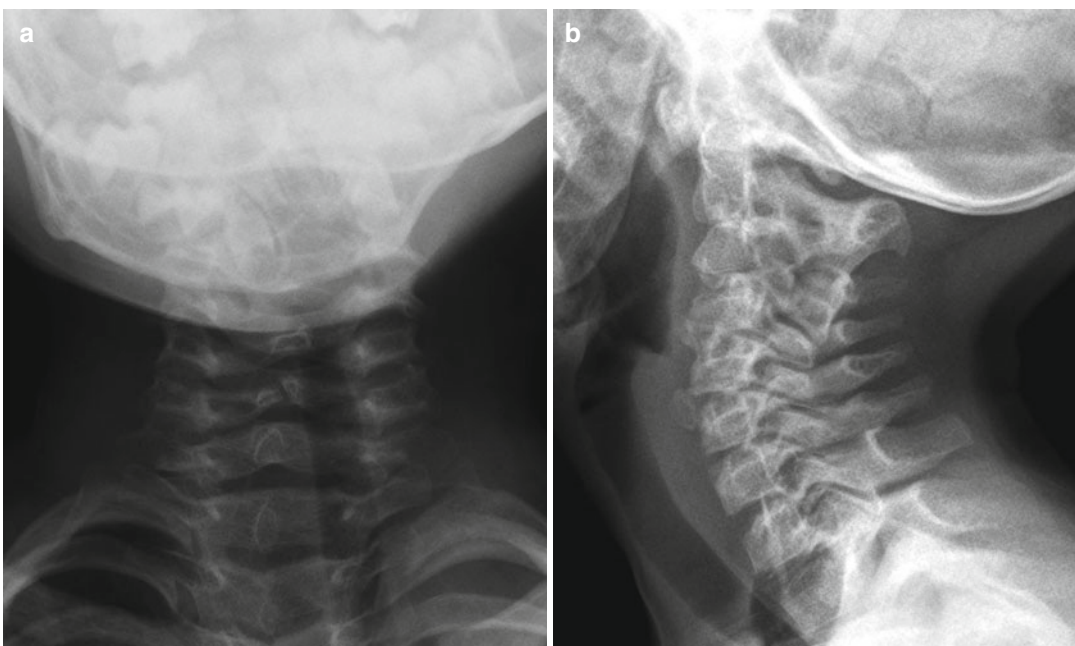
A 5-year-old boy with known Goldenhar syndrome recently developed a slight tilt of the cervical spine. AP (1.8.5.1) and lateral (1.8.5.2) radiographs of the spine
